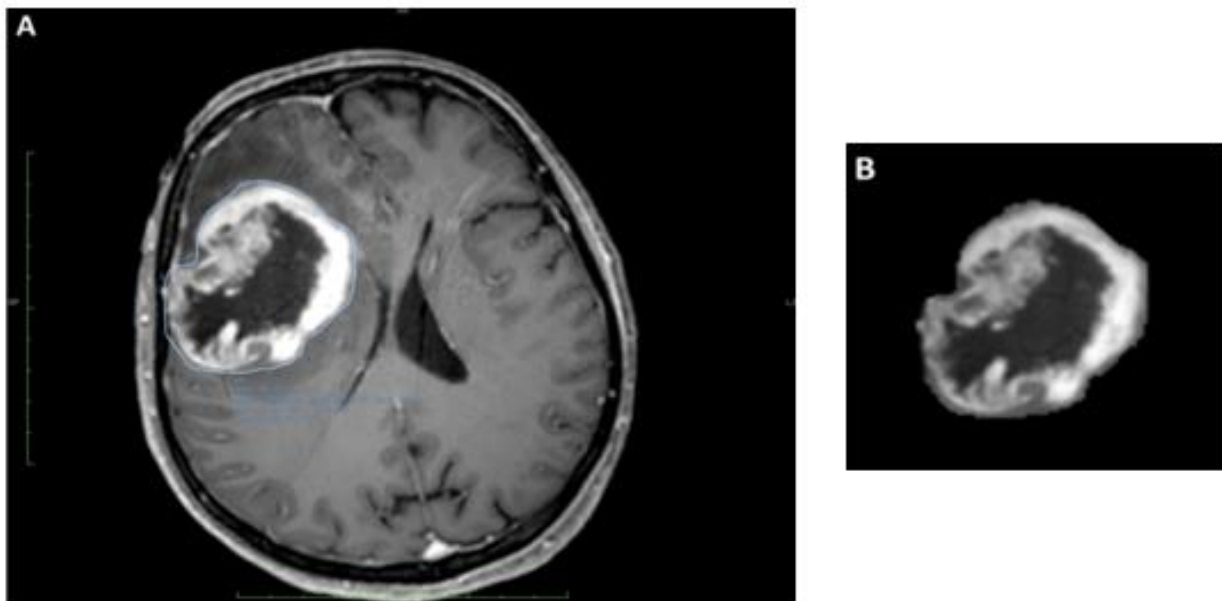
A: T1w+Gd MRI image of a patient with GBM. B: ROI extracted from the segmented region
